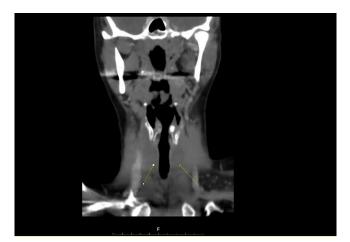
Bilateral abscess cavities seen on coronal CT (Yellow arrows).
